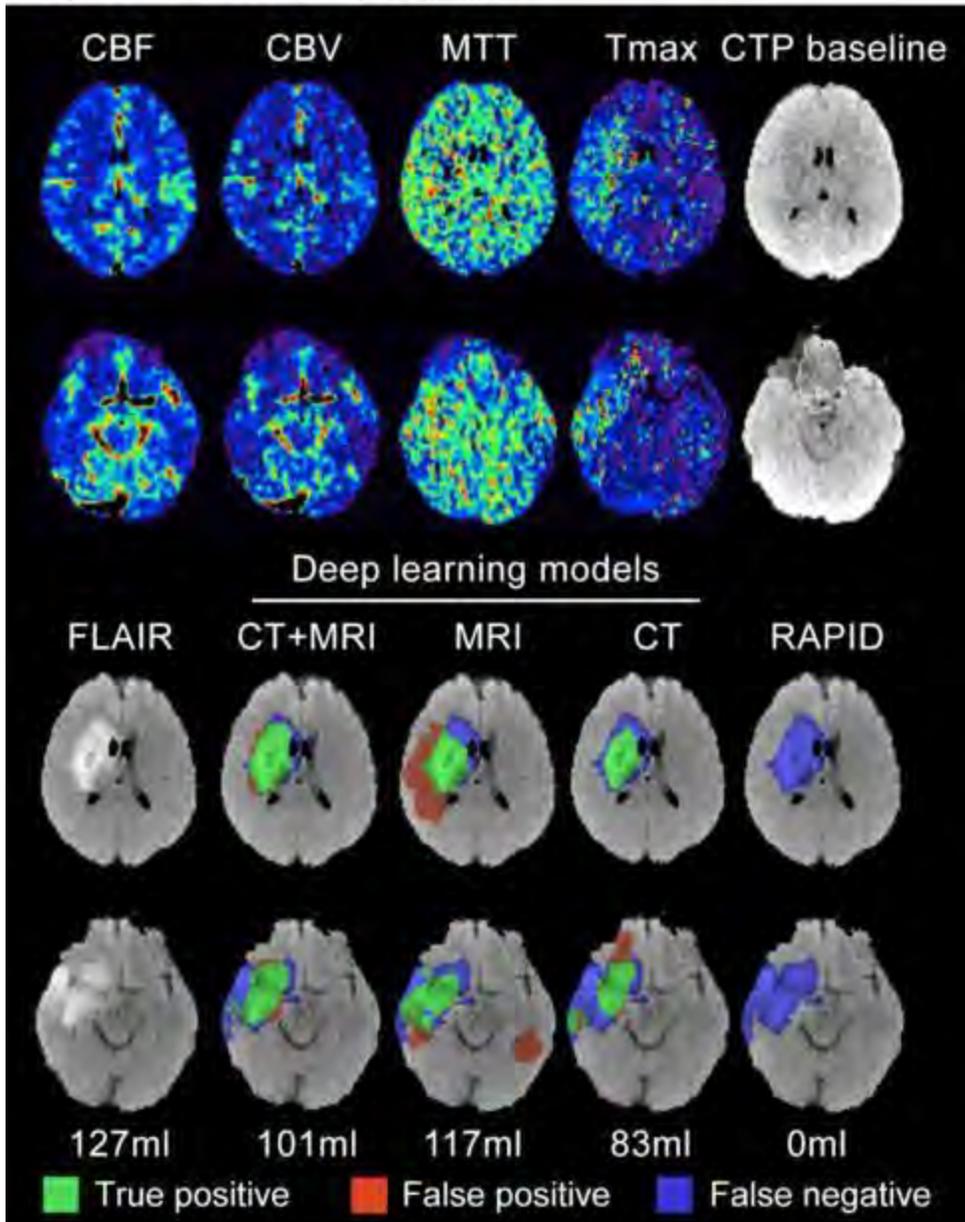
A patient with baseline NIHSS of 15 and TIC1 3. The top two rows are two slices of baseline CT perfusion images with cerebral blood flow (CBF), cerebral blood volume (CBV), mean transient time (MTT), Tmax, and pre-contrast CT. The bottom two rows are two slices of 5-day FLAIR, model prediction from CT fine-tuned MRI mode, MRI model, CT model, and rCBF≤30% segmentation on RAPID software. The green area represent true positive, blue area is false negative, and red area is false positive.
